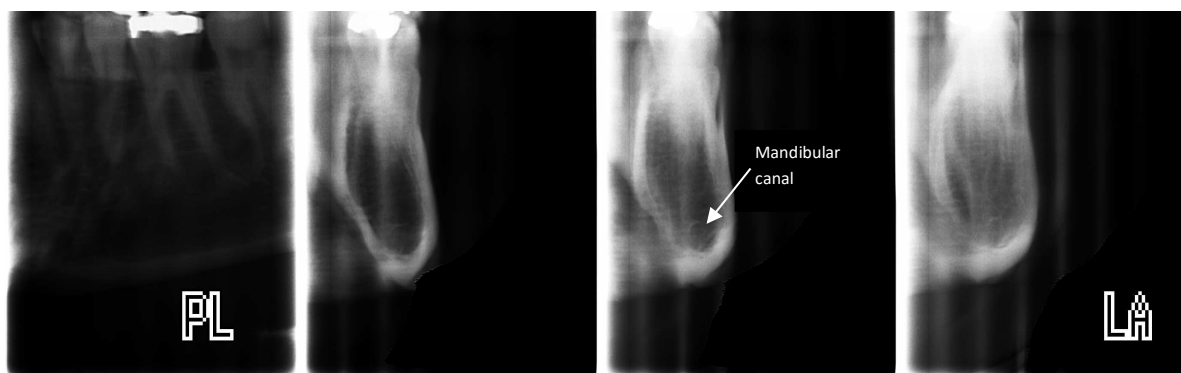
tomographic radiograph (3xCRS 1 LNG) showing the buccal cortical bone
